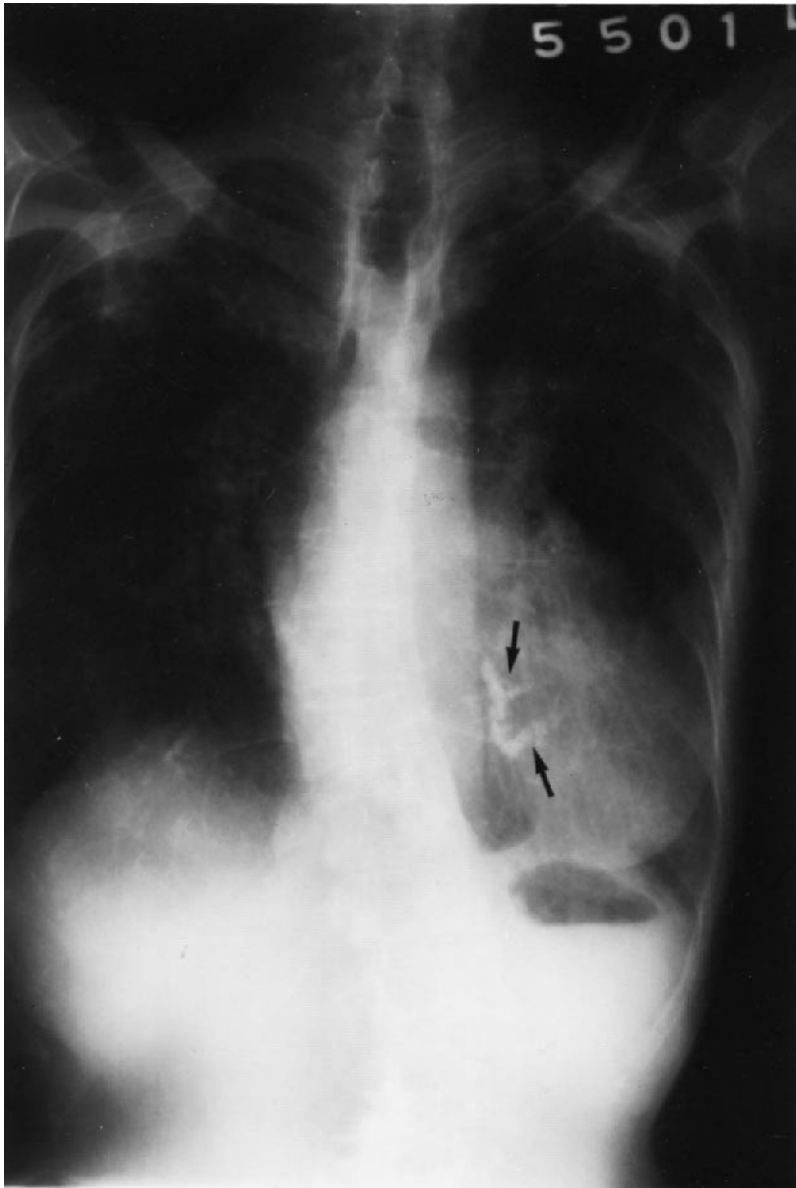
Posterior-anterior chest x-ray in a patient with C-shaped calcification of the mitral annulus (arrows).
